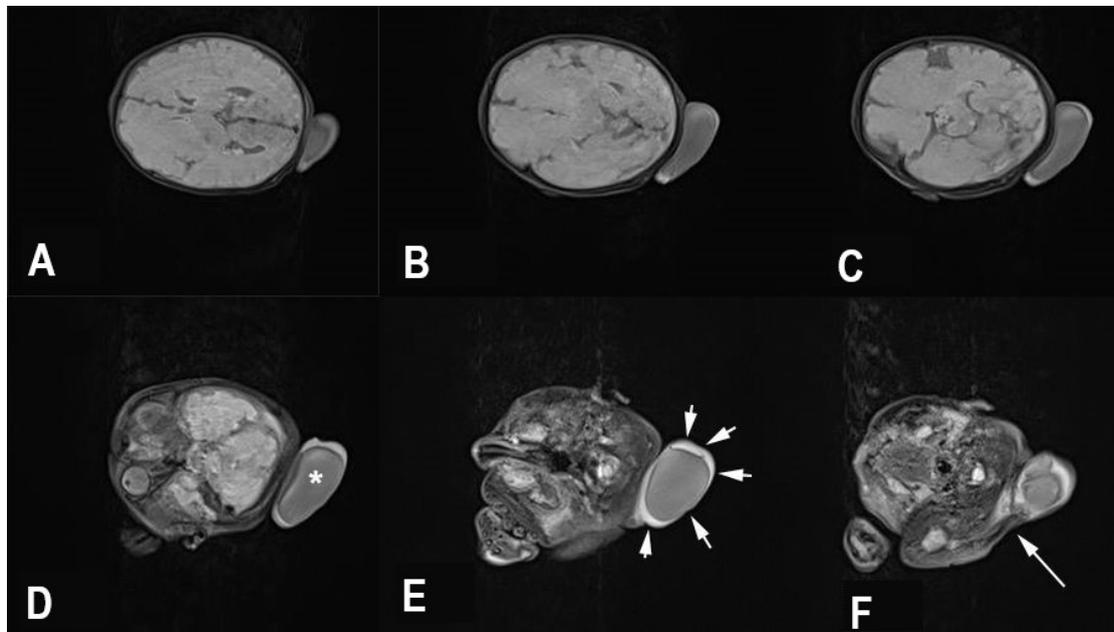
Neonatal MRI. A-F: T2-weighted images, axial sections. D: The meningocele sac (Asterix). E: Skin covering the meningocele sac (Arrows). F: The connection to the spinal canal (Arrow).
